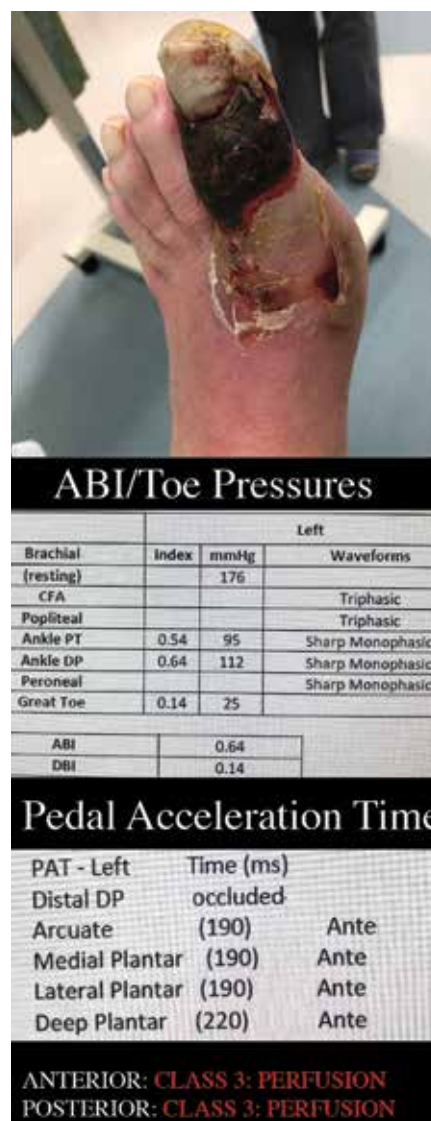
Pre-angiogram arterial ultrasound assessment showing PAT Class 3, moderate arterial insufficiency in the foot. PAT = plantar acceleration time.
